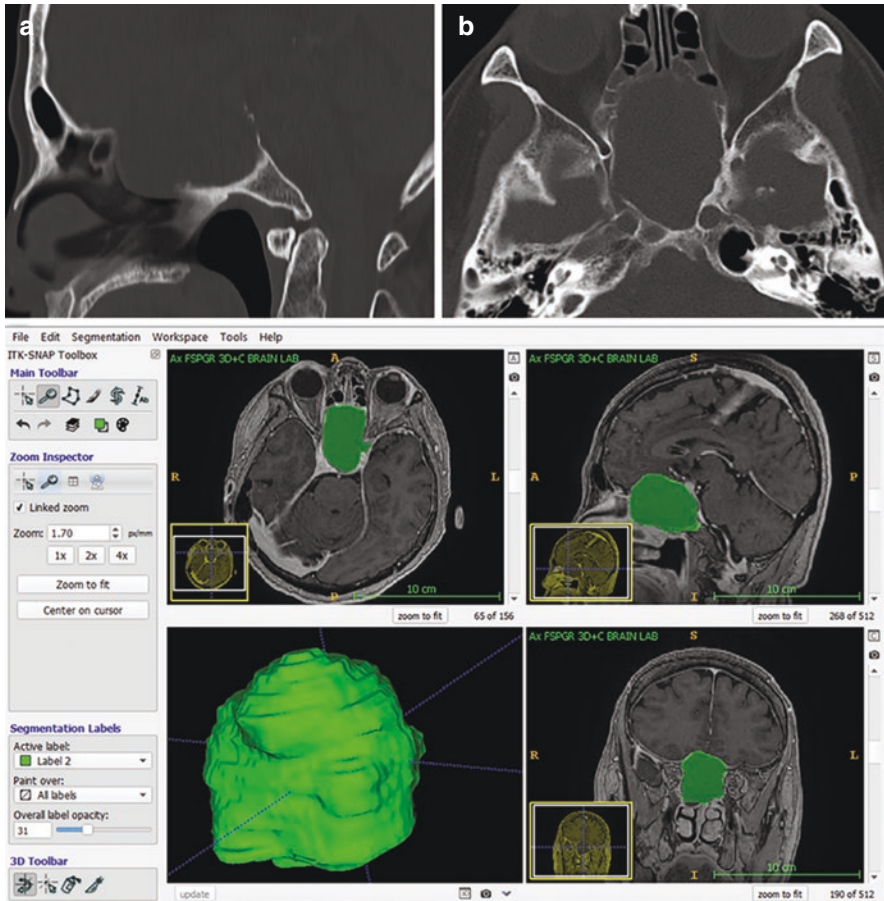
Isolated giant fungal mucocoele of the sphenoid sinus. Preoperative CT images (a, b) and preoperative volumetric analysis using ITK-Snap software
